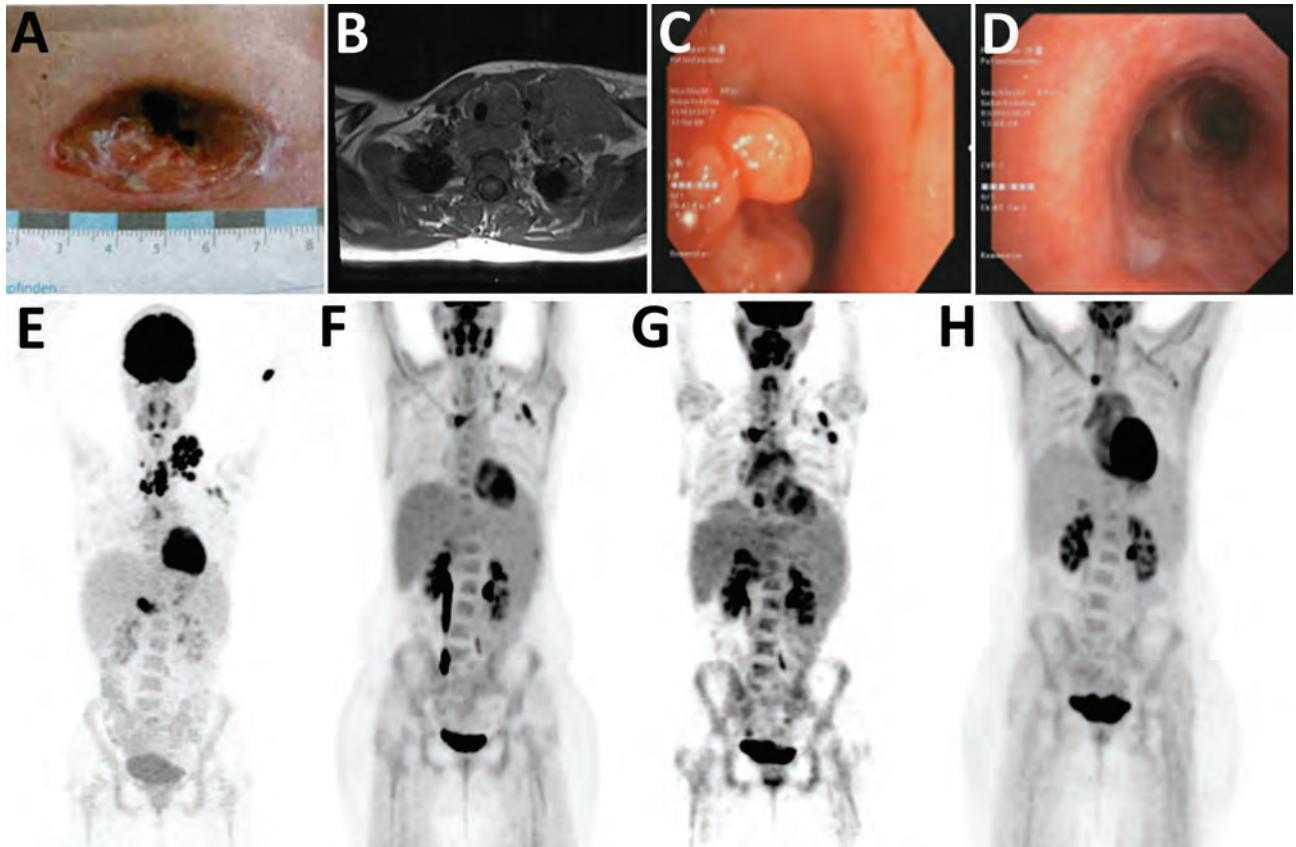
Clinical manifestations and radiologic findings in the course of disease in a 23-year-old woman with disseminated *M. genavense* infection preceding Hodgkin lymphoma, Germany. A) Cervical wound after initial lymph node extirpation. B) Magnetic resonance imaging at the time of initial evaluation. C) Endobronchial view of tracheo-esophageal fistula before positioning of a stent. D) Endobronchial view of the prior tracheo-esophageal fistula after treatment. Whitish scar tissue is seen at the bottom left. E) ^{18}F -FDG-PET scan at initial evaluation (maximum intensity projection). Cervical lymph node mass is seen, with no pathologic uptake in the abdomen. F) ^{18}F -FDG-PET scan after 6 months of antibiotic treatment showing reduced uptake. G) ^{18}F -FDG-PET scan shortly before Hodgkin lymphoma was diagnosed showing new hepatosplenomegaly and lymphadenopathy. H) ^{18}F -FDG-PET scan after antibiotic and chemotherapy without pathologic enhancement
